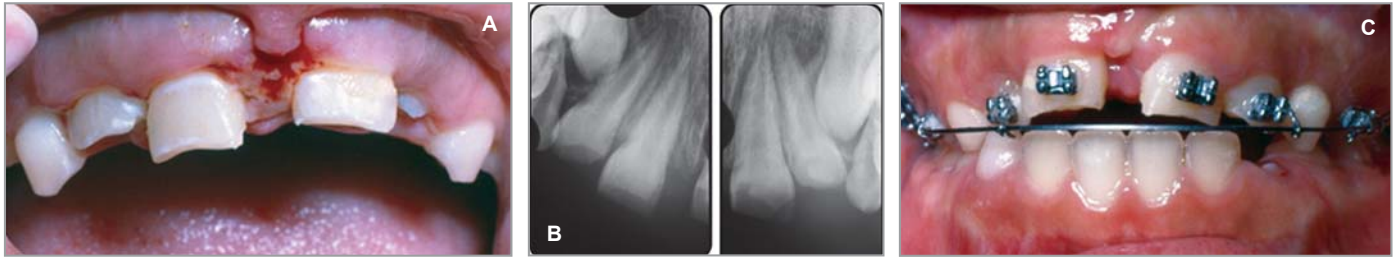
(A) All maxillary incisors except the right central have been intruded to some extent. (B) Radiographs show complete root formation and no fractures. (C) Teeth were extruded by using orthodontic appliances.
